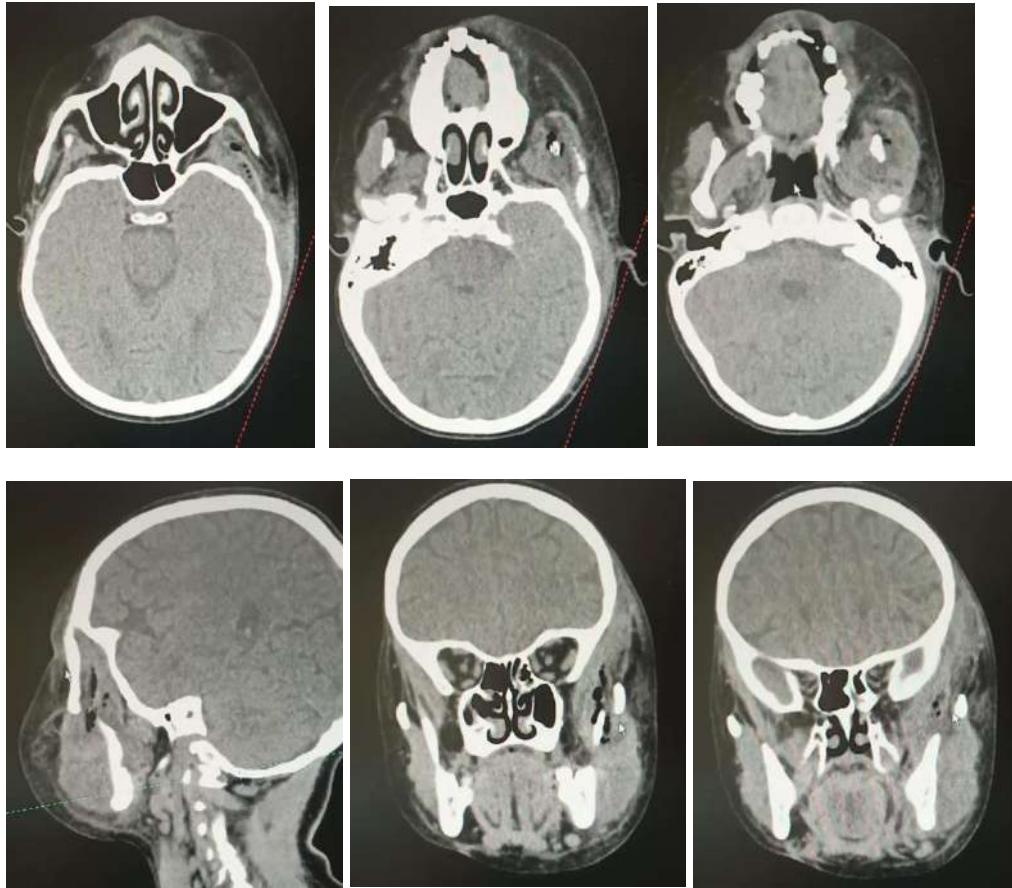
CT scan of the face and neck without contrast was obtained to assess deep space infection
